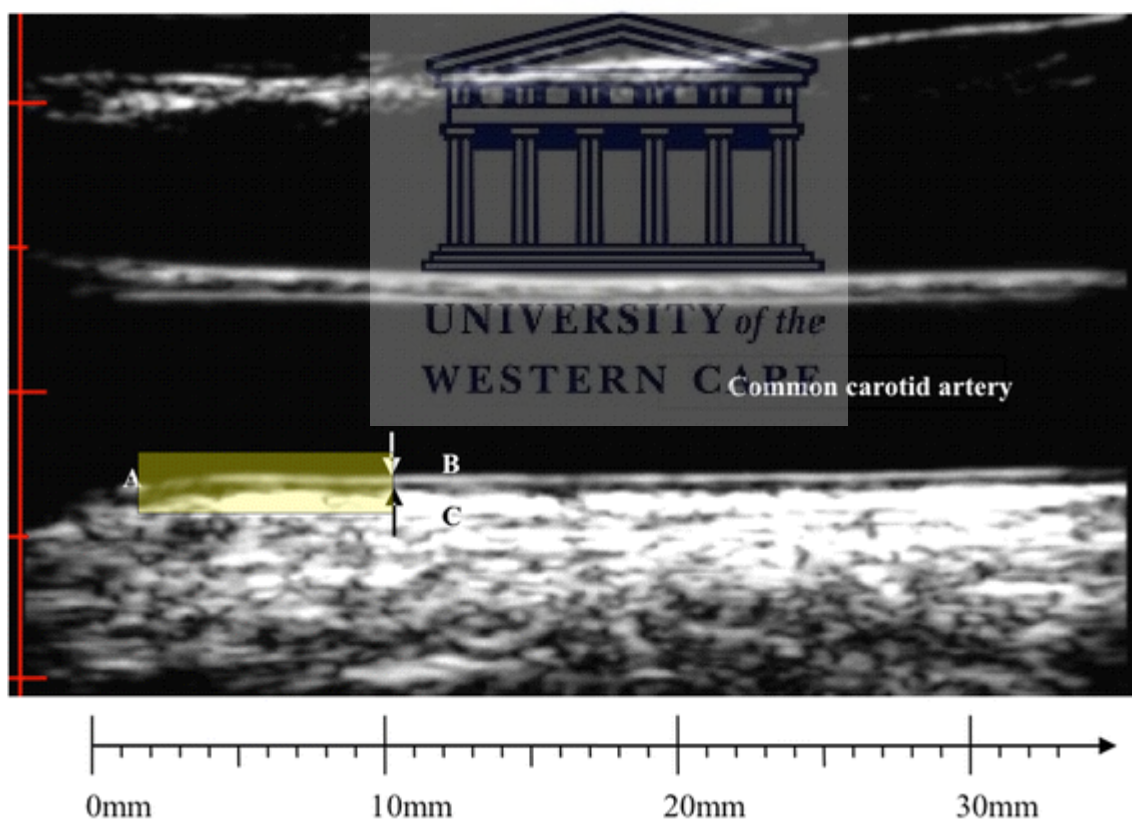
An ultrasound image of the common carotid artery (CCA): (a) border of carotid bulb widening (0 mm), (b) CCA far wall lumen-intima interface, (c) media-adventitia interface. Definitions of the CCA segment for measurement differ depending on study and convention
